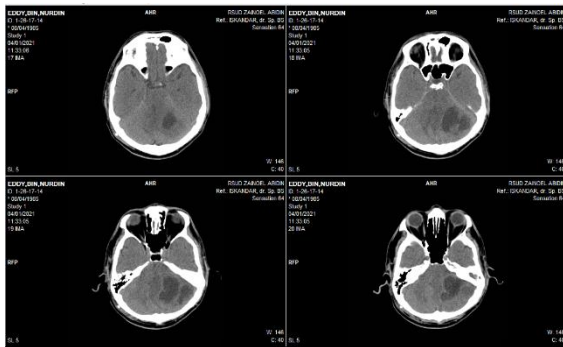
CT Scan of the head post-VP shunt
